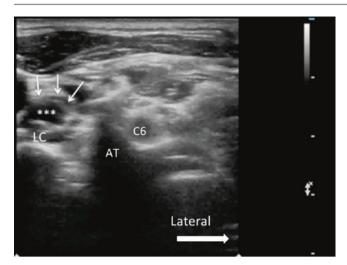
Ultrasonographic image of the neck at C6 level showing the local anesthetic spread within the prevertebral fascia following the injection. *C6* C6 nerve root, *AT* anterior tubercle of C6, *LC* longus colli muscle, *arrows* prevertebral fascia; * local anesthetic. (Reproduced with permission from Philip Peng Educational Series)
